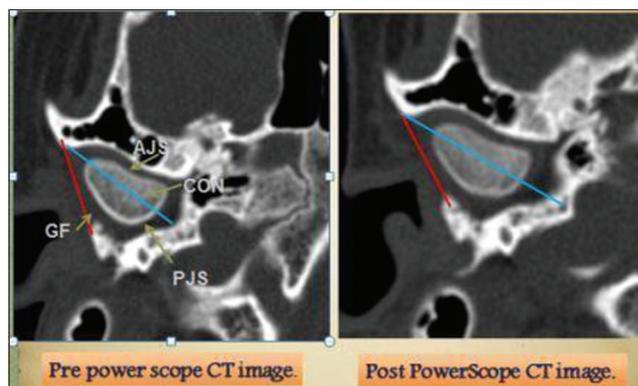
Pre- and post-treatment computed tomography images
